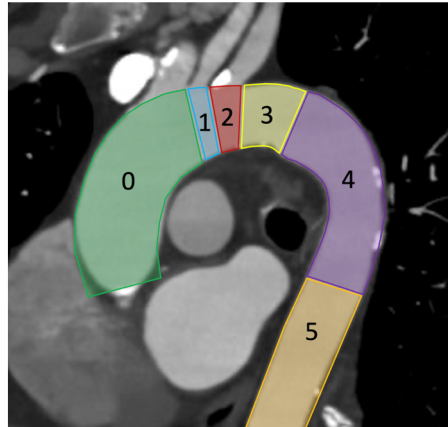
Multiplanar reconstruction (MPR) of a computed tomography angiography (CTA) scan of the aortic arch showing the landing zones according to Ishimaru's classification.
